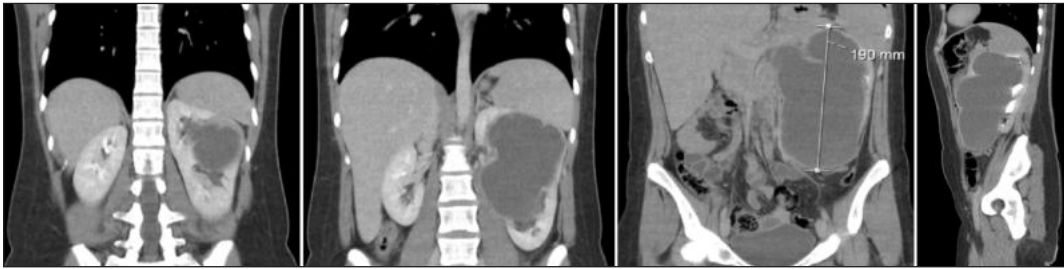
Cystic mass on the left side in the computed tomography sections.
